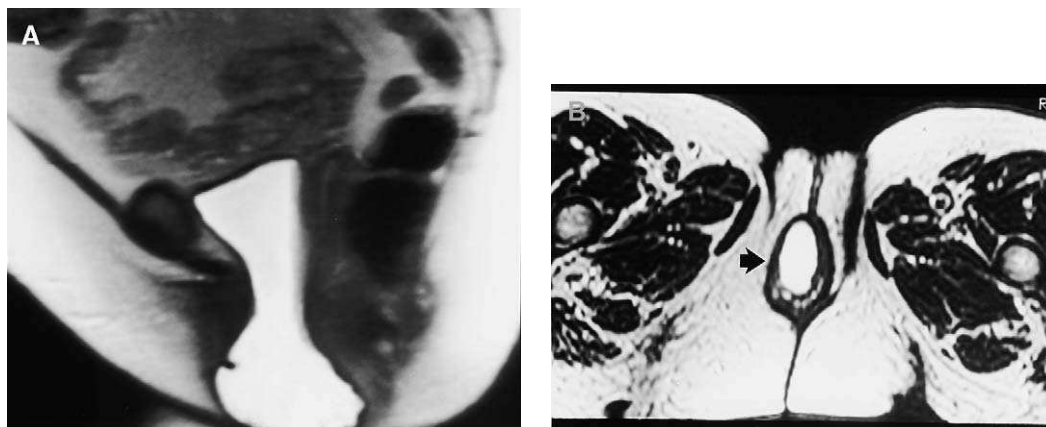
Pelvic pressure and protrusion of tissue through the pelvic floor in a 68-year-old woman. (A) Sagittal T2-weighted image of the patient at strain shows global pelvic floor weakness with a severe cystocele and moderate descent of the uterus and rectum. (B) Axial T2-weighted image (4400/12) shows the bladder protruding through the labia (arrow). (From Fielding JR. Practical MR imaging of female pelvic floor weakness. Radiographics 2002;2:295–304; with permission.)
